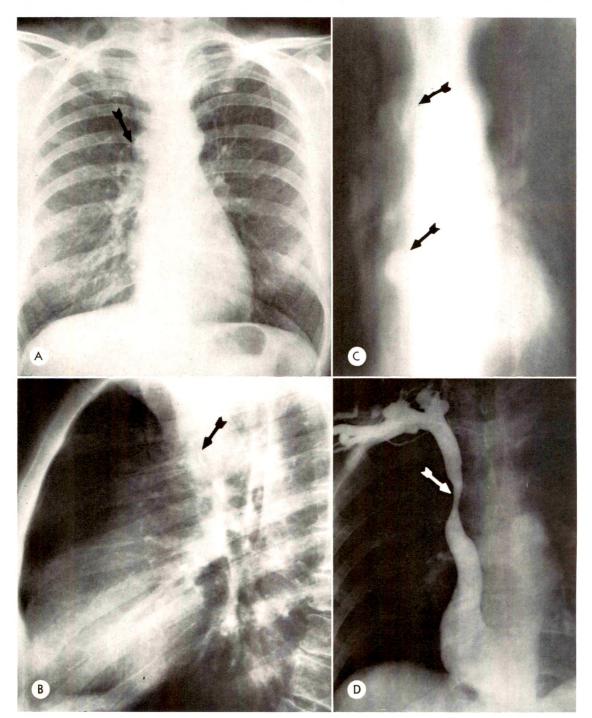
Case II. (A) Frontal teleroentgenogram of the chest showing a small, partially calcified, 2×2 cm. mass in the right paratracheal area (arrow). (B) Lateral roentgenogram showing the middle mediastinal location of the partially calcified mass (arrow). (C) Laminagram showing the paratracheal mass (upper arrow) and another one at the right hilus (lower arrow). (D) Frontal angiocardiogram showing the markedly narrowed superior vena cava (arrow). Note the dilated subclavian and jugular venous channels above.
